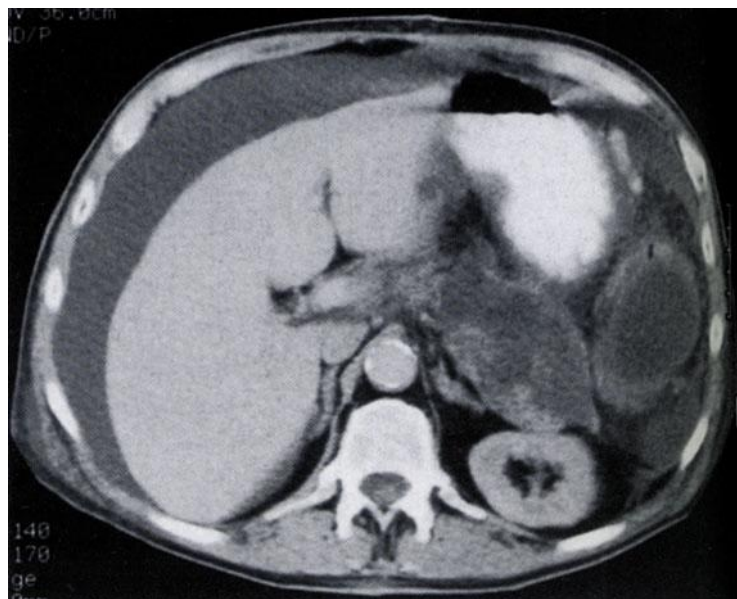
Computed tomography of a patient with a pancreatic pseudocyst rupture and PA. Laparocentesis allowed to gain liquid with a protein content of about 30 g/l and amylase activity higher than 10000 units (according to C.A. Seiler et al., 1998 [11]).
